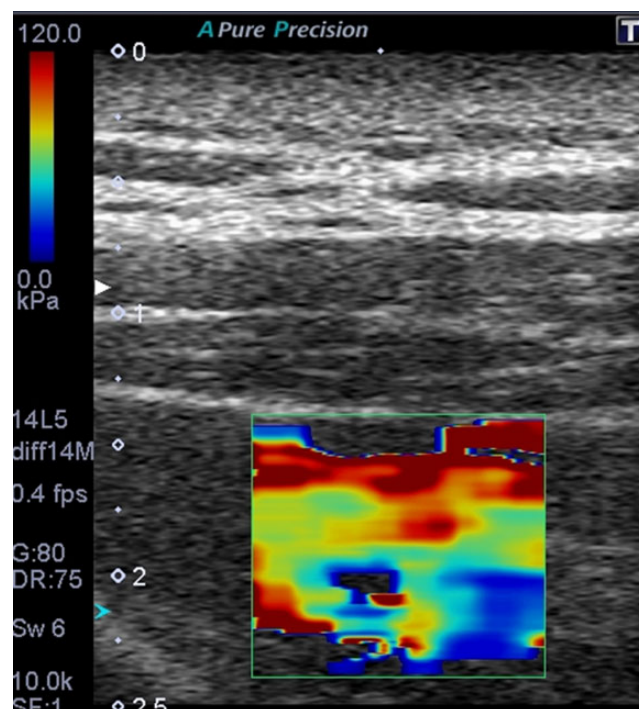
Assessment of shoulder muscle stiffness using shear wave elastography. Shown is an ultrasound image of the supraspinatus. A color-coded box showing the shear elastic modulus is superimposed on the B-mode ultrasound image.
